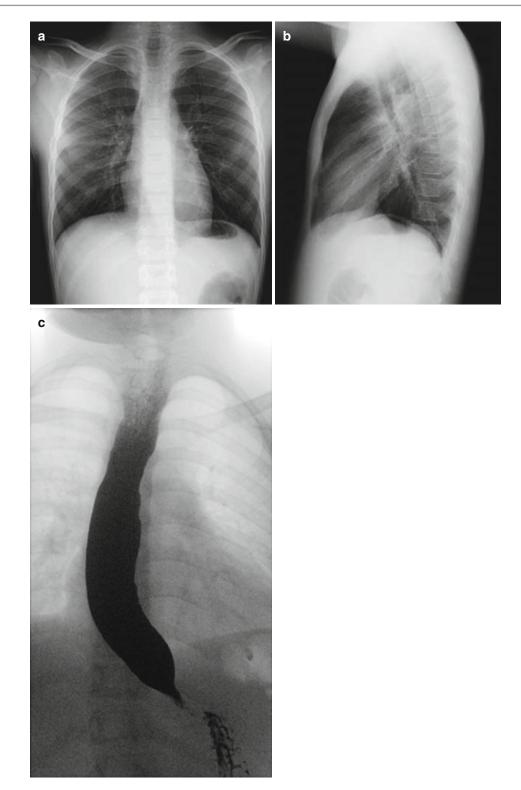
(a–c) Achalasia. (a) AP and (b) lateral chest radiographs reveal an air-fluid level in the distended esophagus. (c) Barium esophagram demonstrating a patulous and dilated esophagus with distal *beaking* deformity
